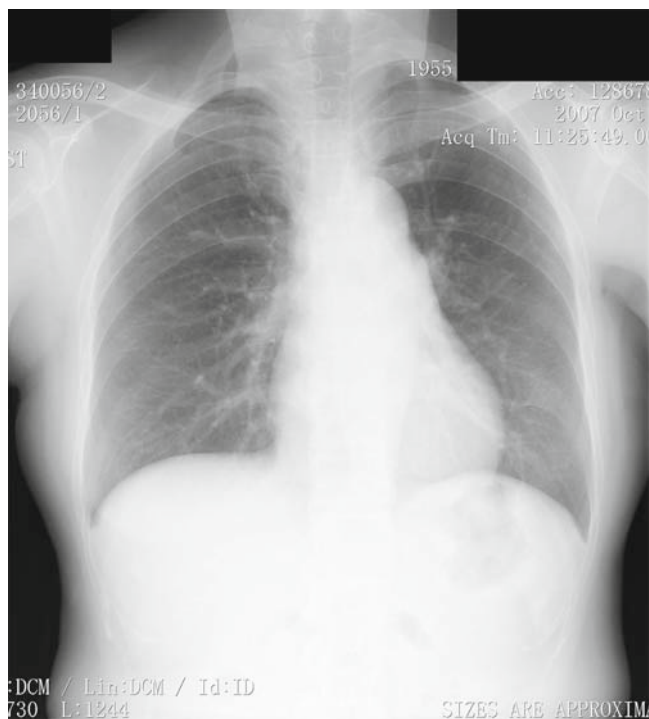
Preoperative chest X-ray could not detect the tracheal bronchus owing to overlap with the mediastinal shadow
